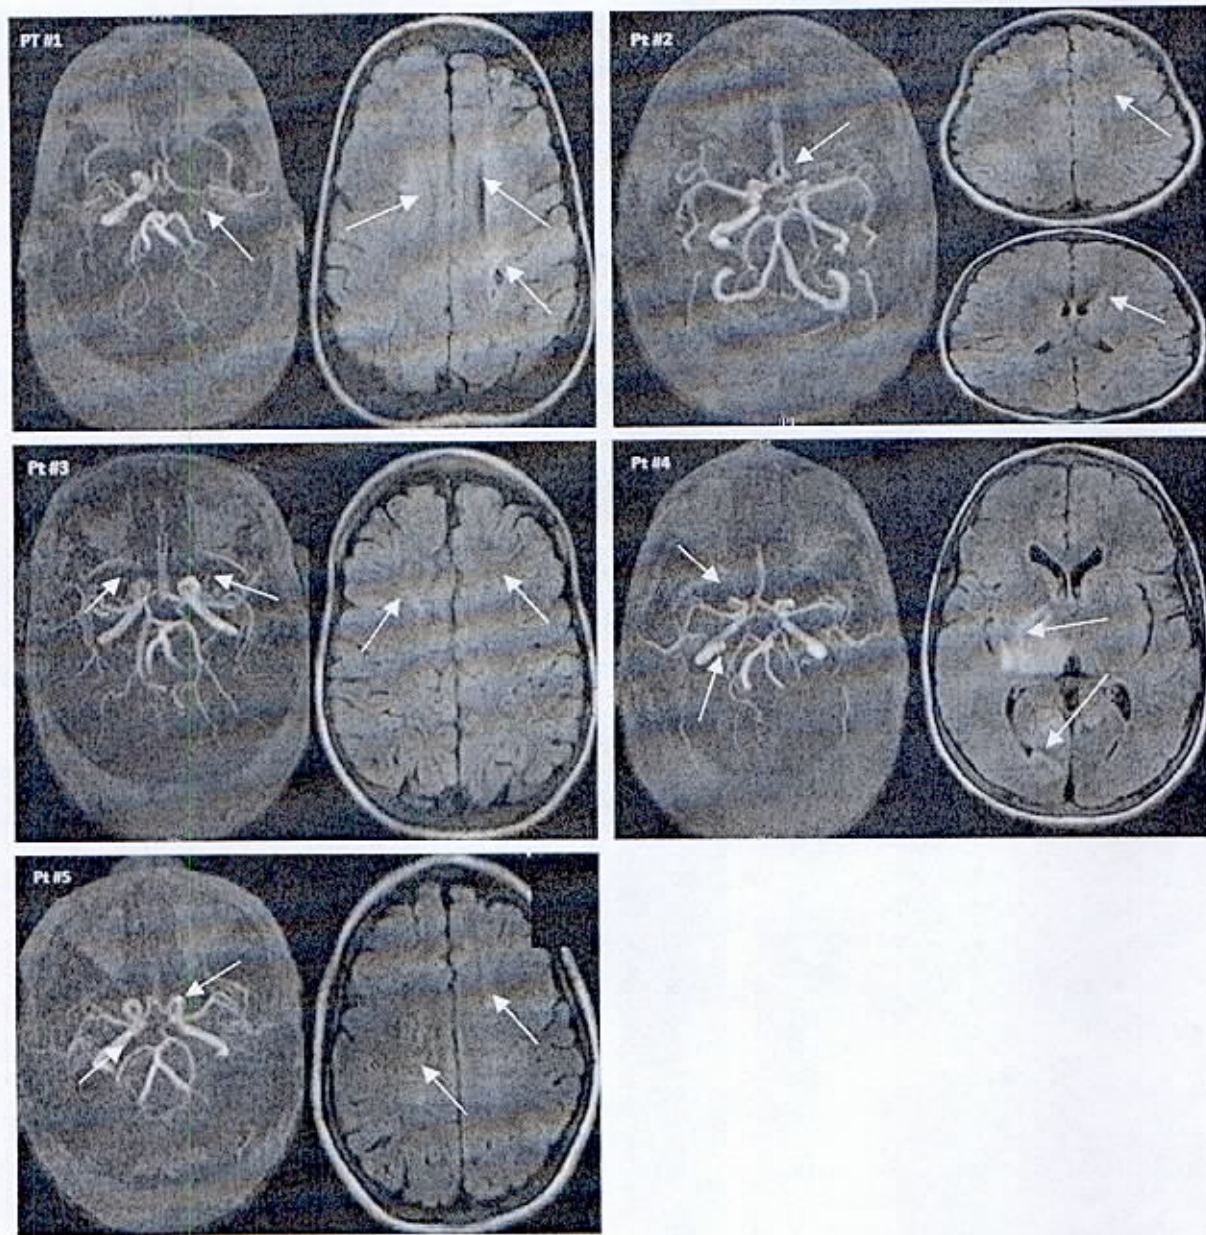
Neuroimaging (MRA and MRI) results for each subject. ↗ identifies impaired vascular flow and corresponding parenchymal views.
